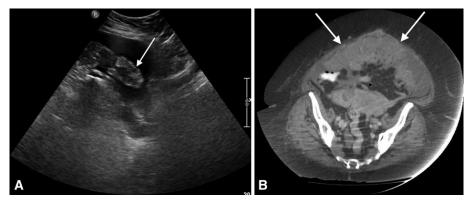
(A) Longitudinal sonogram, showing omental cake (arrow) in a patient with ascites; the finding was overlooked during the initial interpretation. (B) Axial contrast-enhanced computed tomography, demonstrating extensive omental involvement (arrows) in the same patient.
